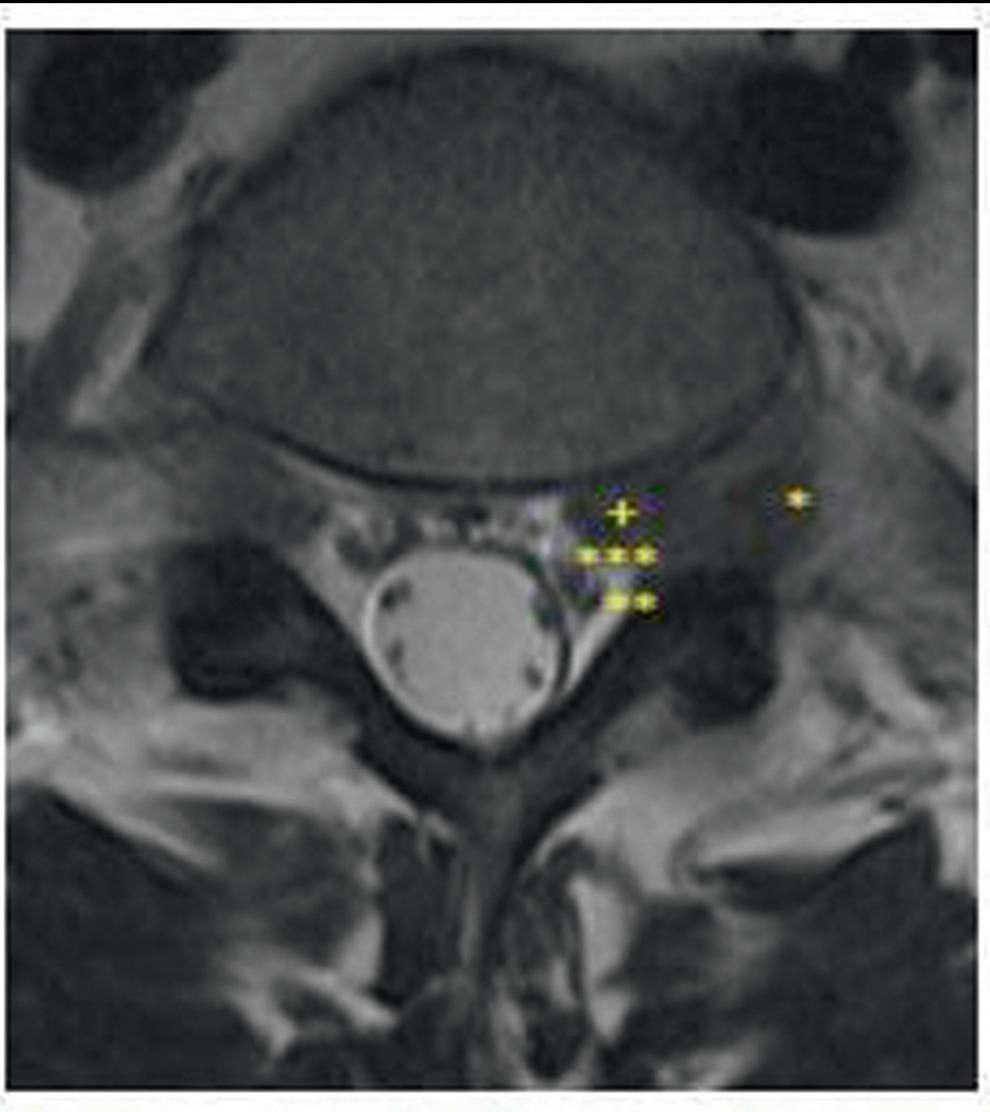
MRI shows disc herniation (+) at level L5-S1. The L5 nerve (*) is compressed passing through the intravertebral foramen. The left lateral recess at disc level L5-S1 contains a sequester (+) of the herniated disc, compressing L5 (*), S1 () and S2 (*) nerves.
